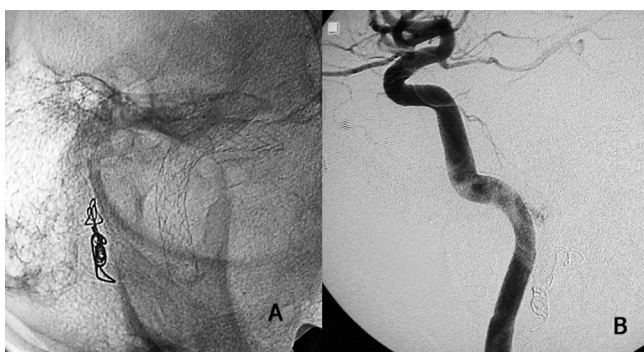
(A) Digital x-ray film in oblique projection showing the stent in the internal carotid artery (ICA) and coils in the external carotid artery from a previous embolization. (B) Digital subtraction angiography of the ICA in lateral projection showing resolution of the stenosis after stenting.
